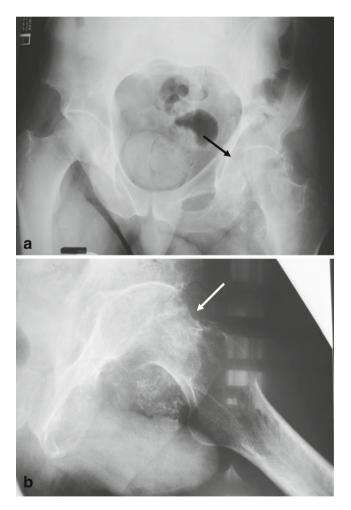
An AP radiograph of the pelvis (a) and frog leg lateral view of the left hip (b) demonstrating irregularly shaped ossific densities in a periarticular distribution in the left hip. Note the loss of definition of the foveal margin of the left femoral head on the AP film (*black arrow*) and area of erosion along the anterolateral margin of the femoral neck on the frog leg lateral (*white arrow*)
